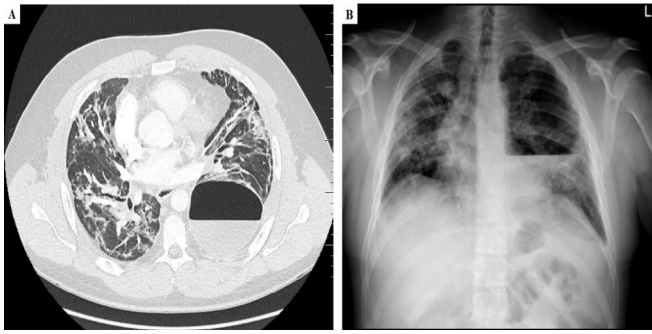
A– Chest CT scan, axial view delineating extend of the lung cyst with air-fluid level B– Chest X-ray showing left side air cyst with air-fluid level.
